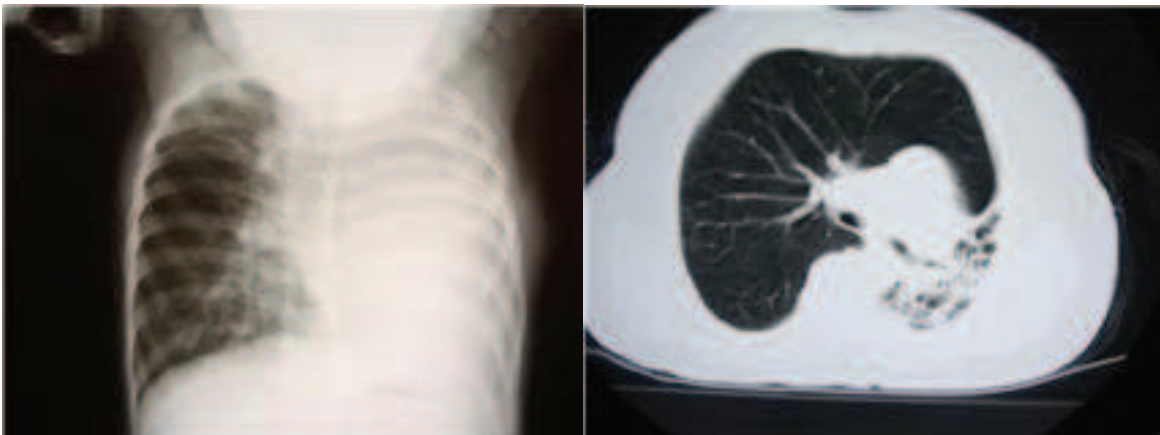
Standart PA chest radiograph and Chest CT scan of a 4-year-old boy shows a destroyed left lung.
